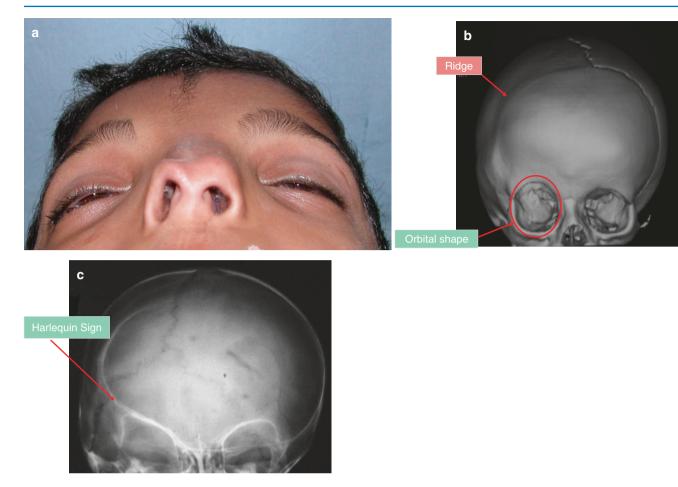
(a) Picture of face showing brachycephaly, hypertelorism and bifid nasal tip. (b, c) 3D CT skull showing unicoronal synostosis, harlequin sign, orbital hypertelorism and facial asymmetry
